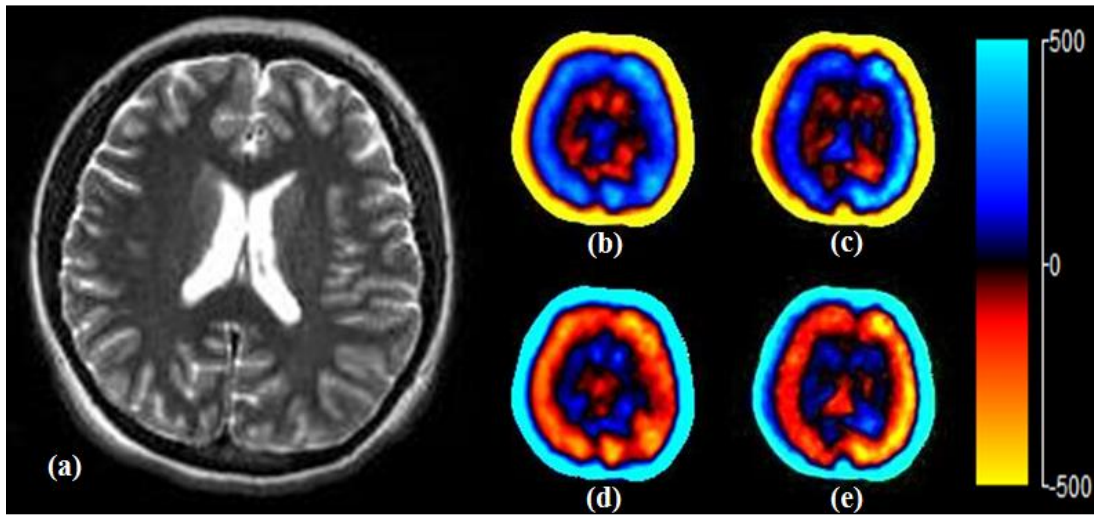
(a) T2-weighted anatomical MR image of the brain of 26-year-old female volunteer (volunteer #8). (b-e) The snapshots of propagating shear wave images of the brain in different time periods.
